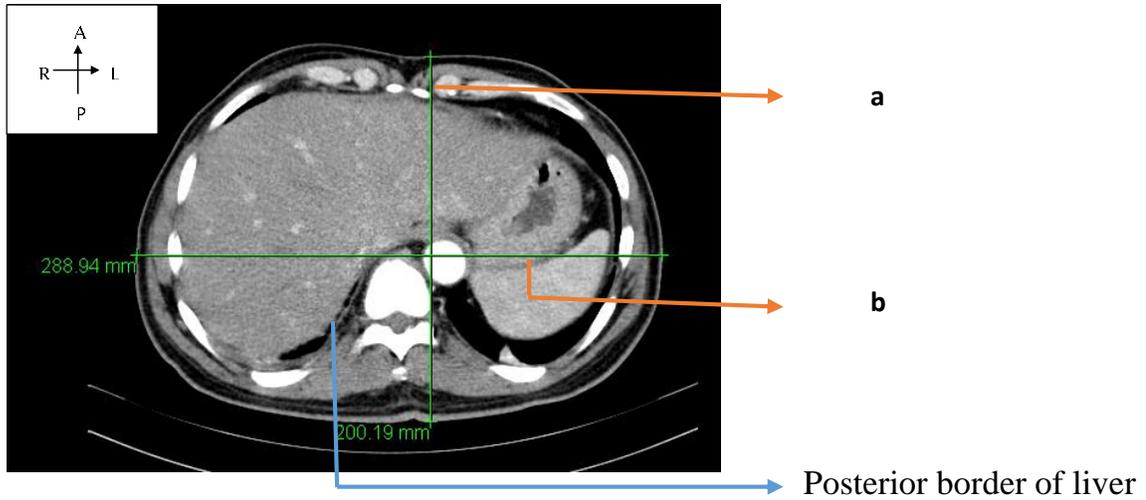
CT Abdomen- Measurements of Tomographic Image - At the Level of Upper Abdomen – Level A1
